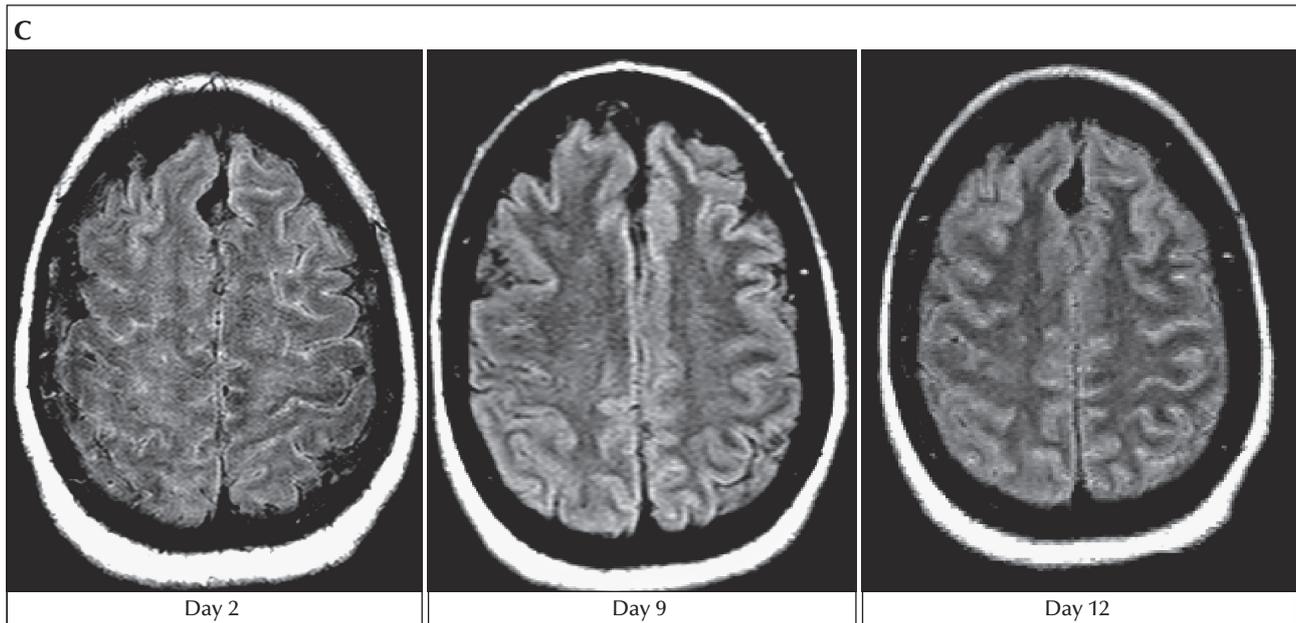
(A) Brain MRI with coronal T2-FLAIR sequence in Patient 1 at times zero, two and three months, respectively, showing FLAIR hyperintensities in bilateral hippocampi and insular cortices that eventually resolved. Generalized brain and hippocampal atrophy with ventriculomegaly was also evident at two and three months. (B) Brain MRI with axial diffusion-weighted sequence in Patient 2 at times zero and one month, respectively, showing diffuse cortical diffusion restriction. In the second image, there is new diffusion restriction demonstrated in subcortical structures, right > left. (C, see next page) Brain MRI in Patient 3 on Day 2 showed diffuse increased T2-FLAIR signal within the sulci, which may have improved on repeat MRI on Day 9, but was visualized again on another MRI on Day 12. The MRI on Day 9 was performed with intravenous gadolinium contrast, whereas the first and last MRI were performed without contrast.
